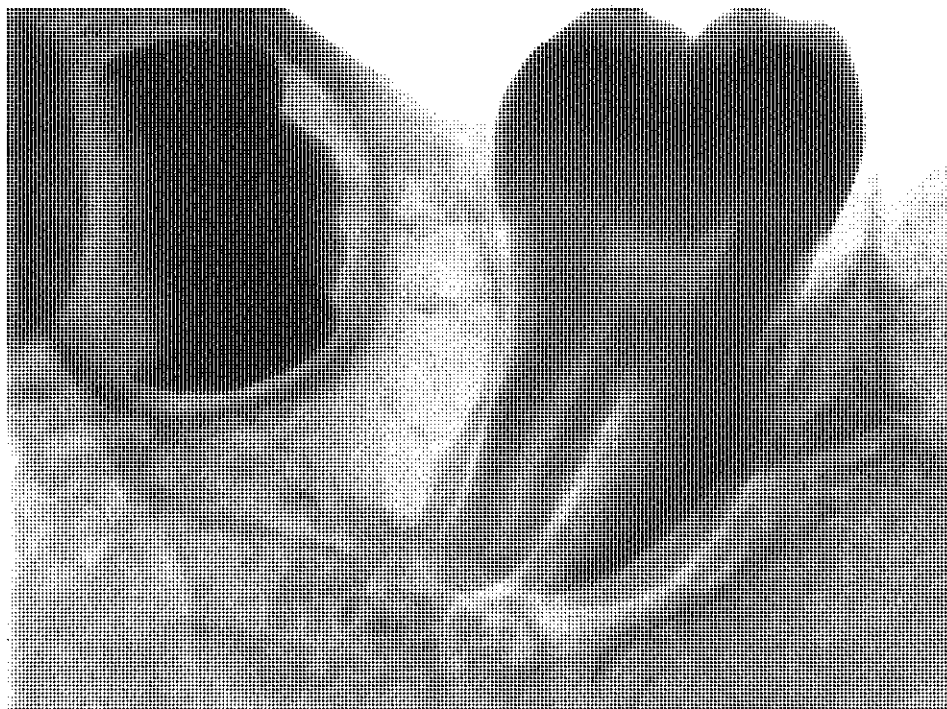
The germ of the left third lower molar (38) in the radiograph.
